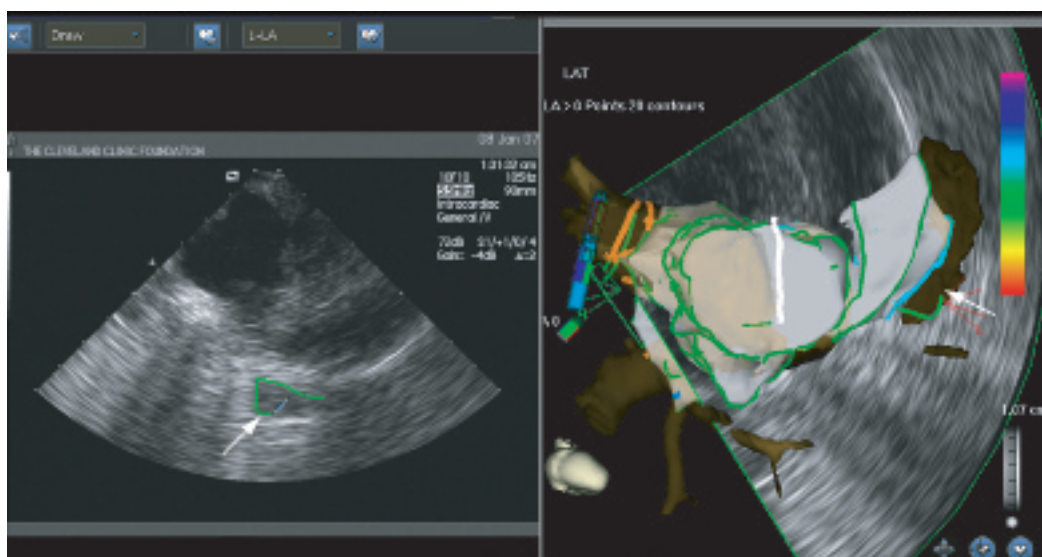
Reconstructing the LAA using ICE-Carto-CT integration.
